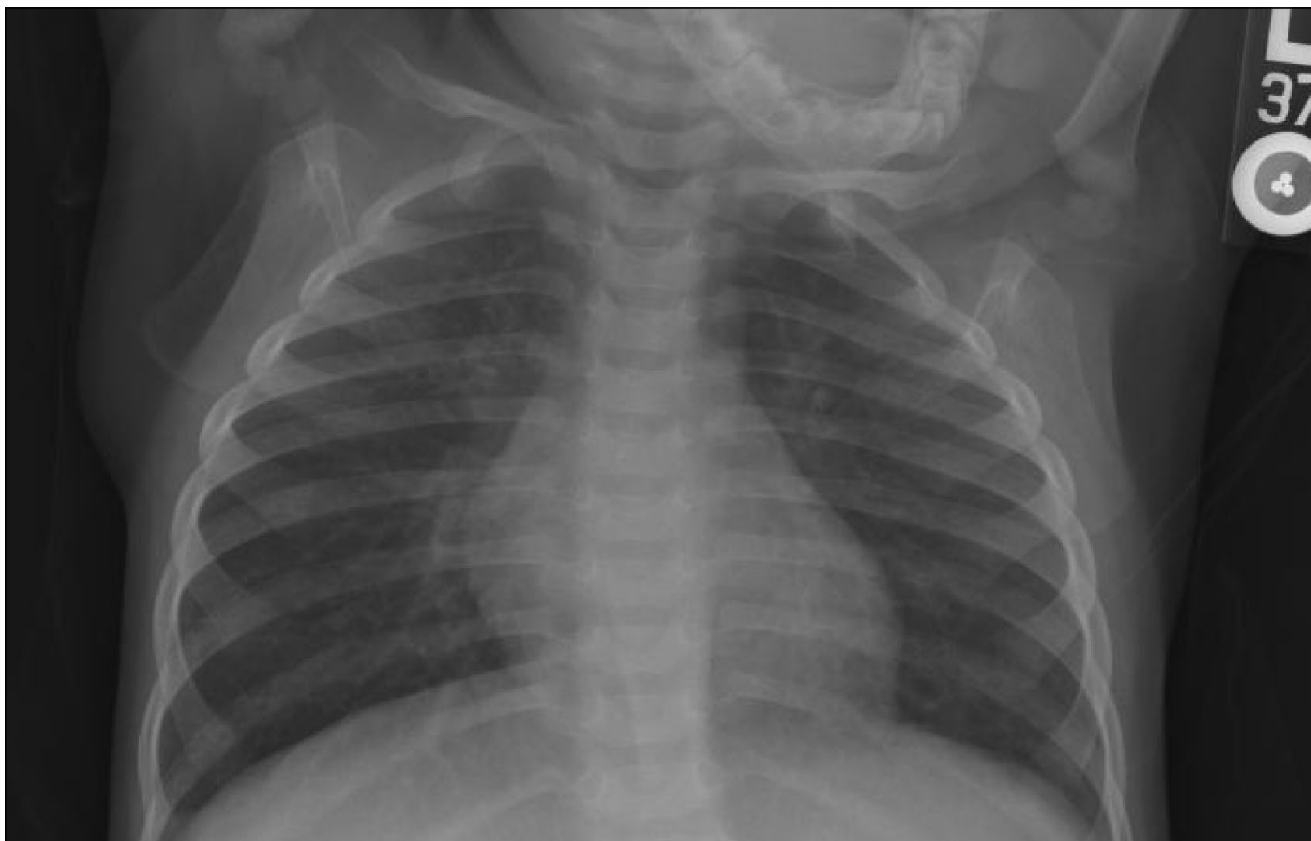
Repeat chest radiograph showing hyperinflation and increased bronchovascular markings, evidence of a diffuse bronchiolar inflammatory reaction.
